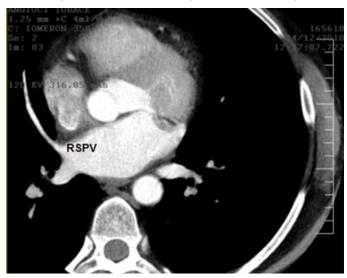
Computed tomography of the heart. A long branch of the RSPV is visible, heading towards the right pleura.
